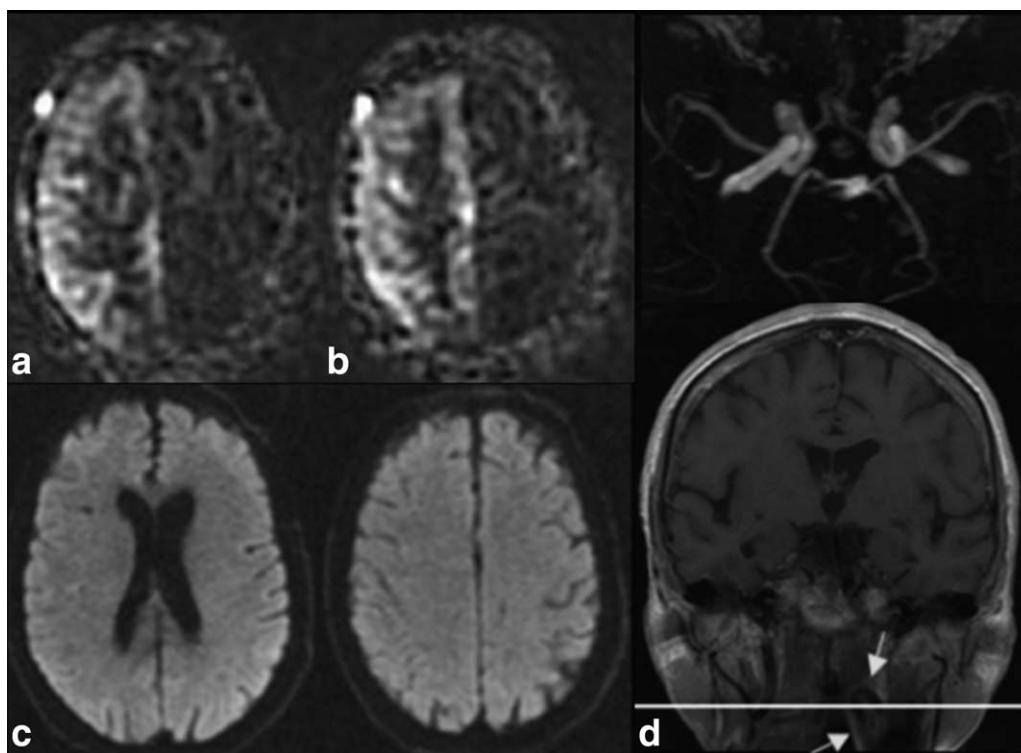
Poor labeling due to vessel tortuosity. a: ASL CBF maps demonstrate an absence of signal in the left ICA territory. b: Collapsed TOF MRA demonstrates normal flow signal in the left ICA. c: There is no evidence of acute infarction as diffusion-weighted imaging (DWI) demonstrates. The absence of corresponding abnormality on MRA and DWI suggests that the low ASL signal is an artifact. Unfortunately, a neck MRA, covering the labeling plane, was unavailable for review. d: The distal cervical ICA is, however, visualized on coronal postcontrast T_1 -weighted images. Marked tortuosity of the left ICA (arrowed) as it passes through the labeling plane (white line) results in the vessel passing through the labeling plane twice; this in turn results in poor labeling efficiency due to multiple inversions. Decreased signal in the right parietal lobe on the ASL CBF maps is an example of the “ASL borderzone sign” (resulting from decreased cardiac output), discussed later in this review.
